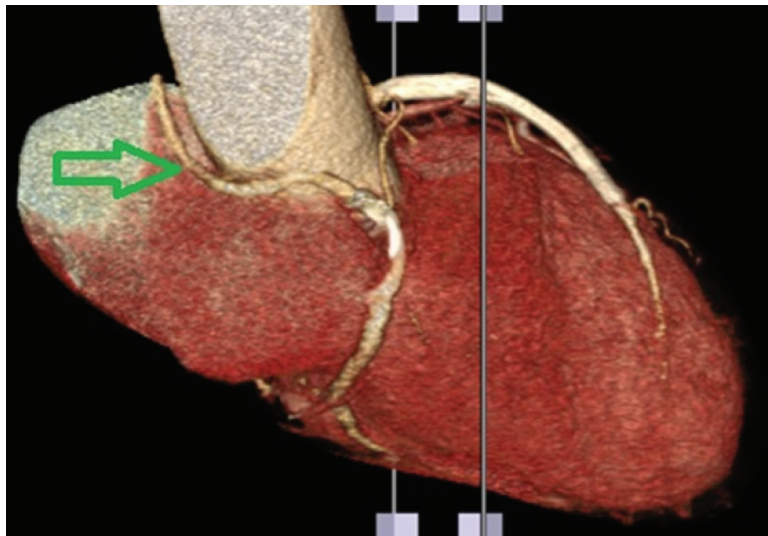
Multislice computed tomography coronarography image of the coronary artery fistula originating from the proximal right coronary artery, located between the aorta and the pulmonary artery.
